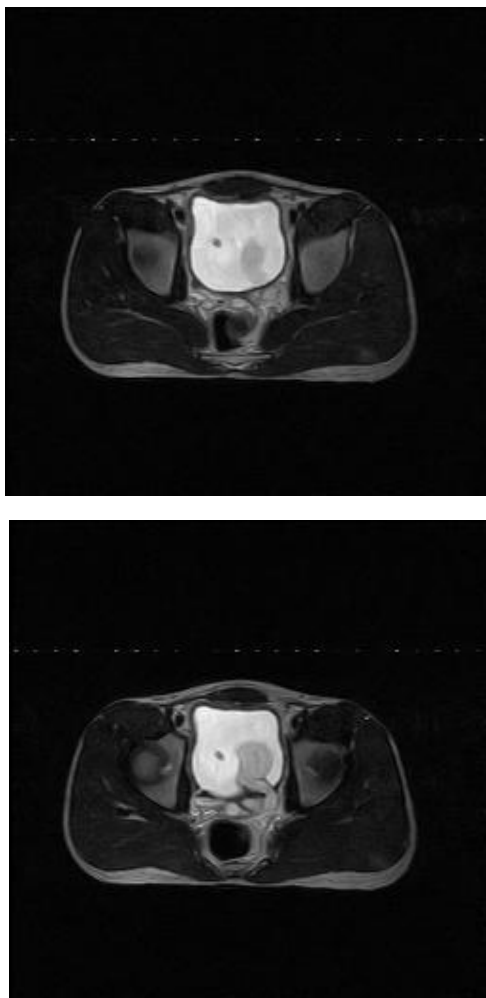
MRI imaging of left seminal vesical cyst
